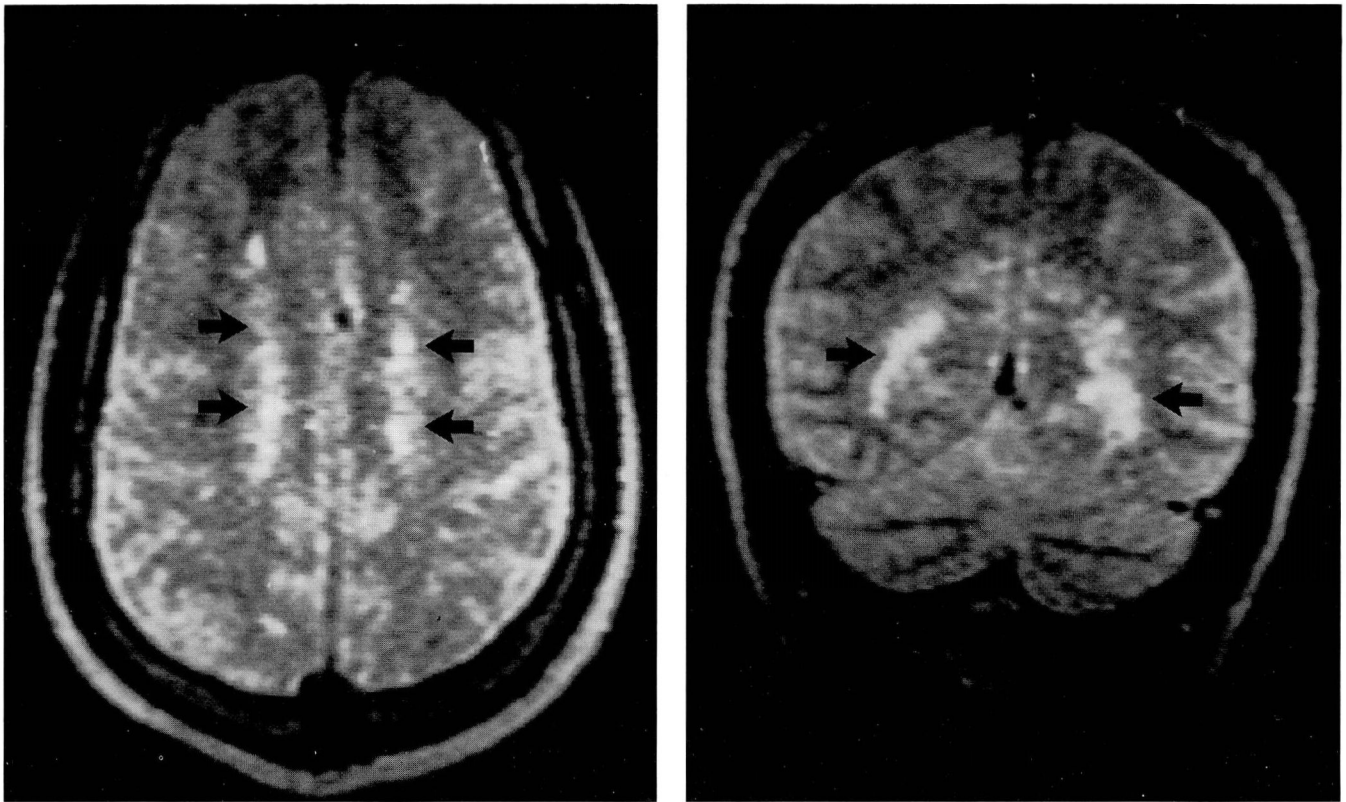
Magnetic resonance imaging of the brain showing focal areas of increased signal intensity in the periventricular area (black arrows) on T2-weighted images. These findings were consistent with a demyelinating disease process involving the periventricular white matter.
